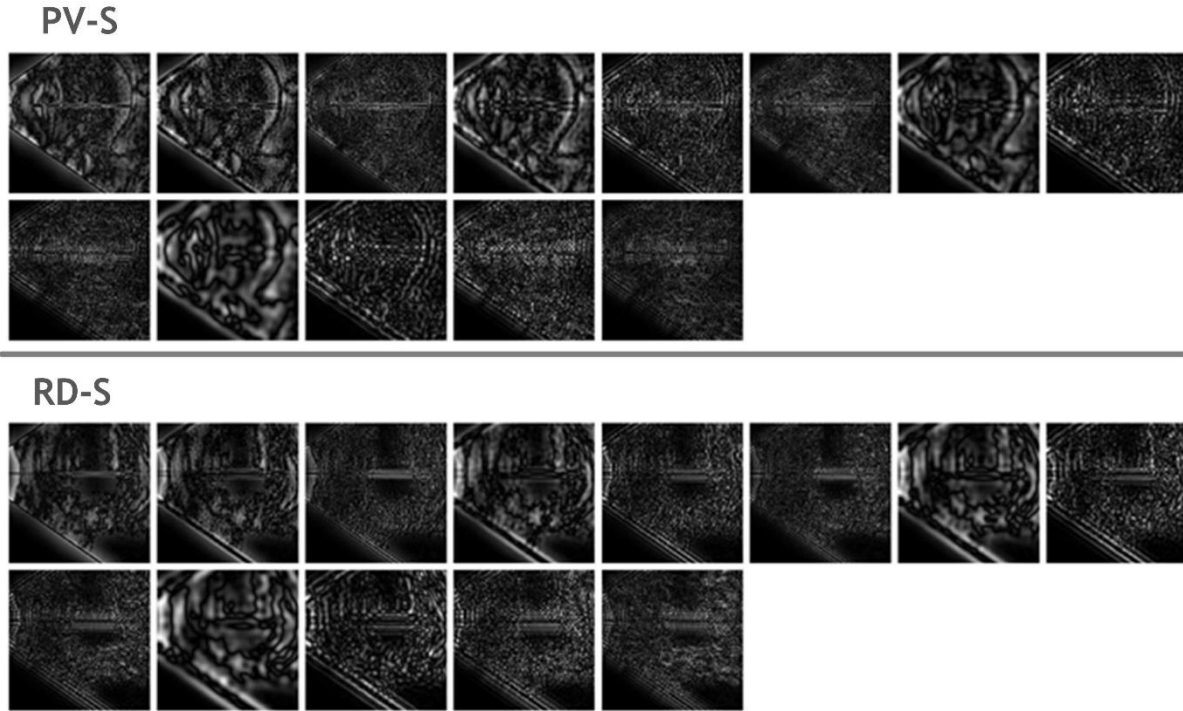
Images obtained after applying LM filter bank to PVD and RD ultrasound images.
